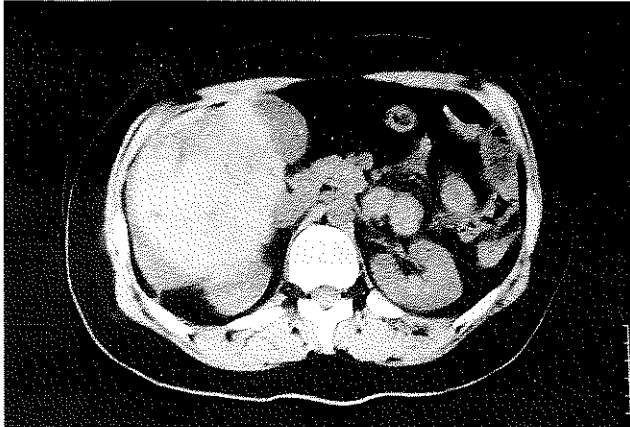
The control CT view of patient on 20th day of trauma. No change was detected in the size of hematoma.
